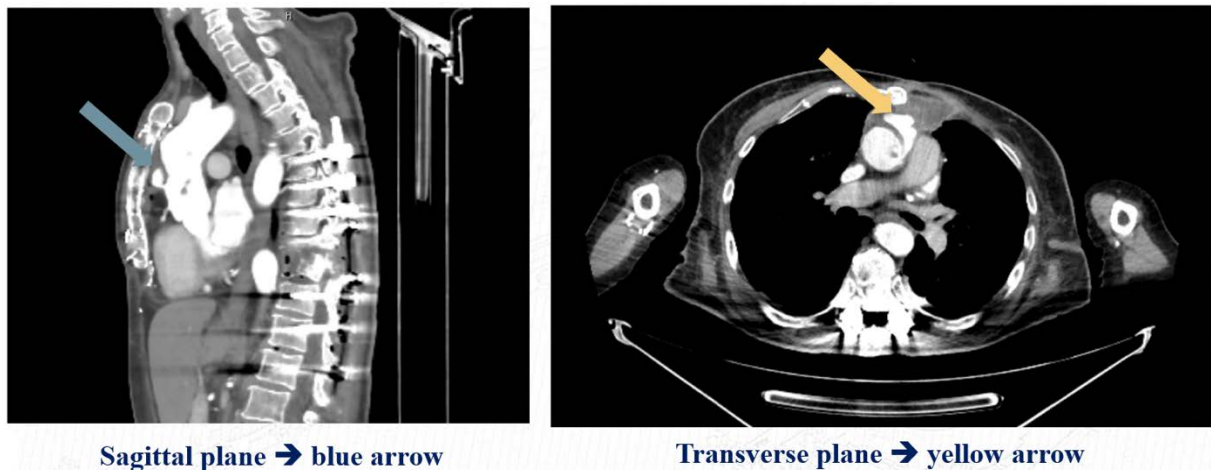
CT sections of thoracic aorta.
